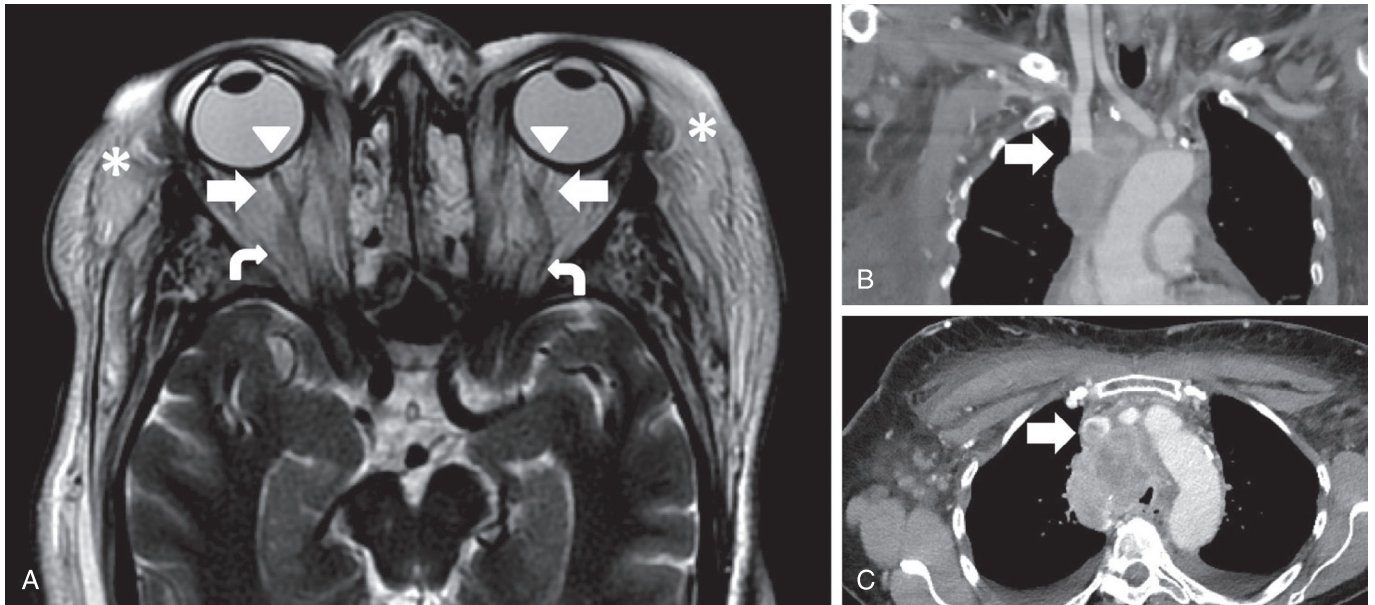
Superior vena cava (SVC) obstruction syndrome. Magnetic resonance findings of pseudotumor cerebri can result from extracranial venous obstruction. (A) A T2-weighted axial image demonstrates mild bilateral optic nerve sheath distension (arrows) with mild bilateral posterior globe flattening (arrowheads). There are also additional findings including diffuse facial soft tissue swelling (asterisks), dilated bilateral superior ophthalmic veins (curved arrows), and bilateral globe proptosis. (B and C) Coronal and axial computed tomography images of the same patient reveal a large mediastinal mass invading and obstructing the SVC (arrows).
